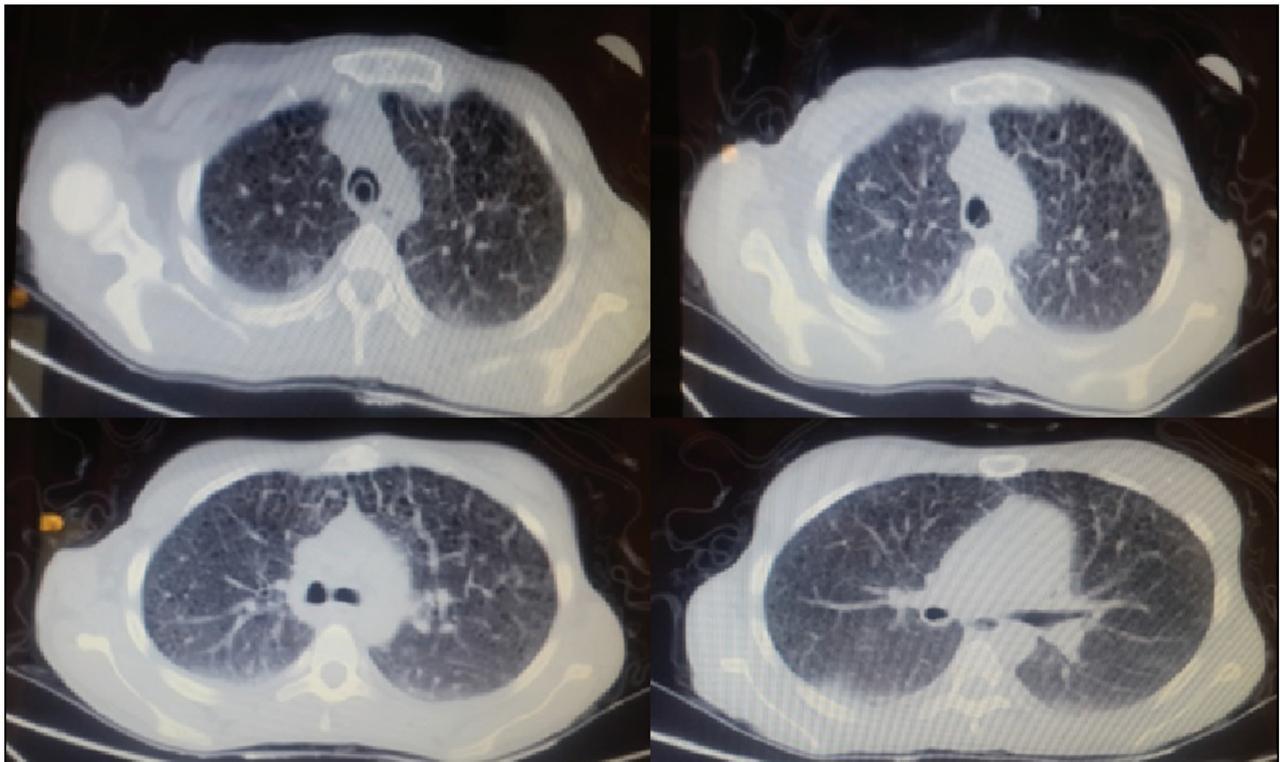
High-resolution computed tomography showing centrilobular emphysema dominant in the upper lobes
